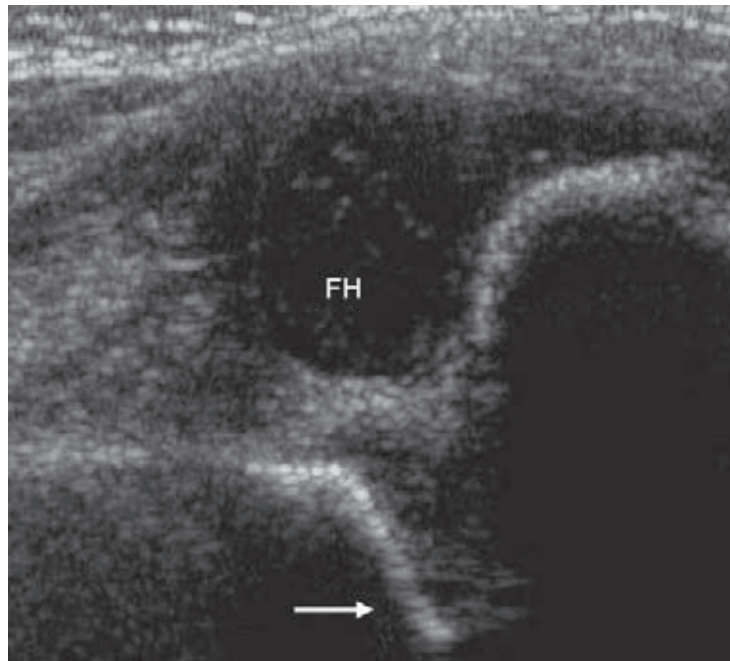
Decentred hip. Coronal ultrasound scan shows the cartilaginous femoral head (FH) lies out with the bony acetabular roof (arrow)
